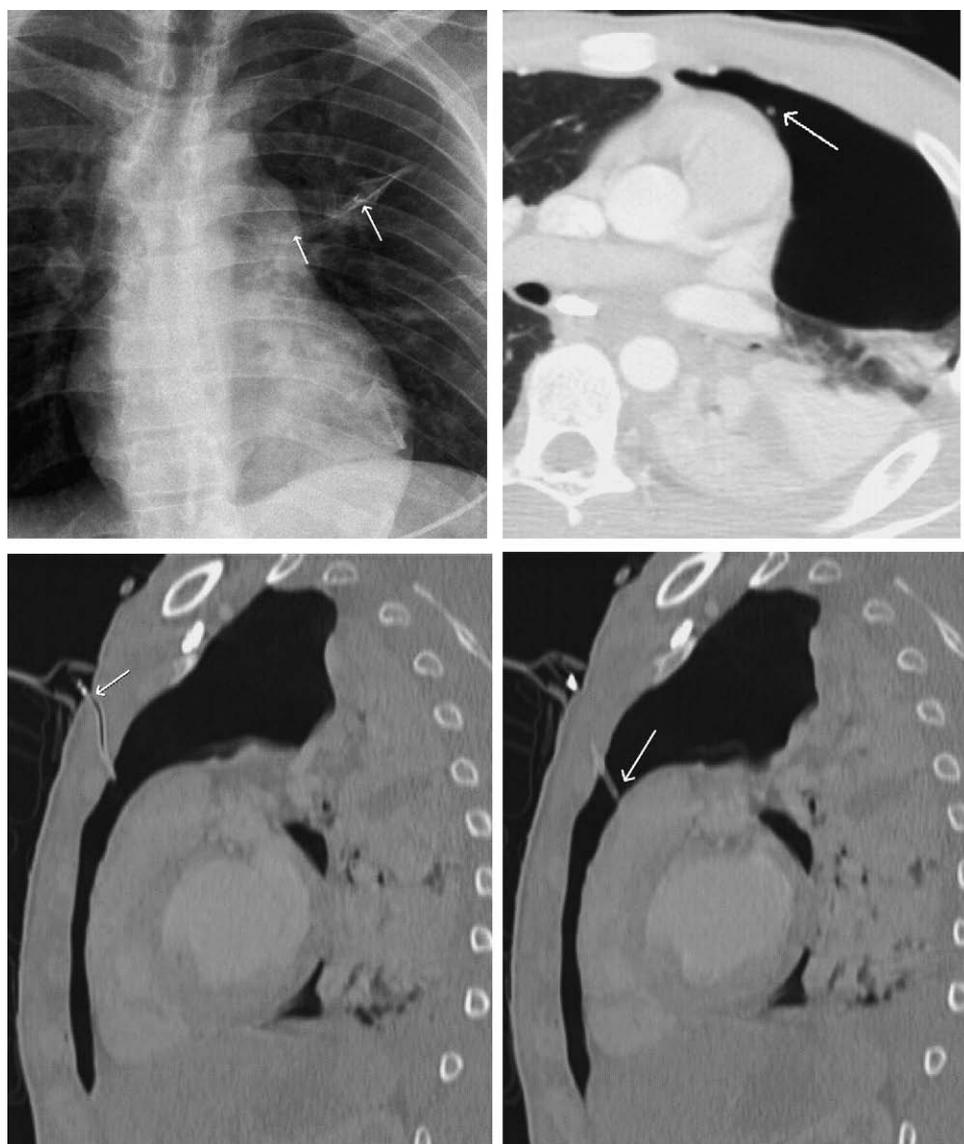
Chest x-ray shows a catheter medially oriented. The axial CT view (top right) shows the relationship of the catheter to the heart. The CT sagittal views (bottom) show the relationship of catheter to the mediastinal structures.
